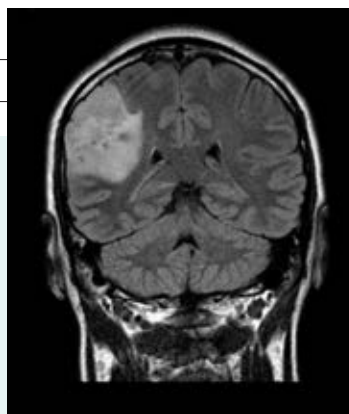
Magnetic resonance imaging (MRI) of the brain with fluid attenuation inversion recovery (FLAIR)
